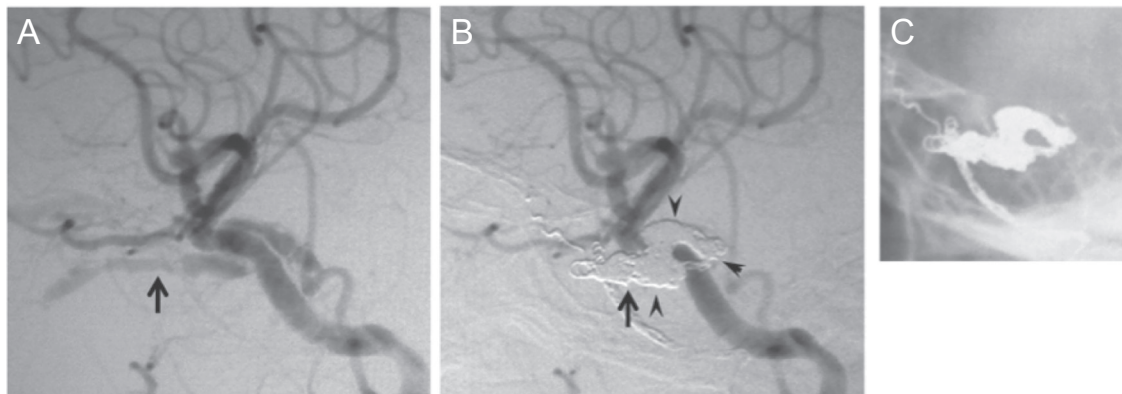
An 84-year-old man with cavernous sinus dural arteriovenous fistula (AVF) underwent transvenous embolization. A: Lateral view of left common carotid angiography showed cavernous sinus dural AVF fed by meningeal branches of the left internal carotid artery. The drainage routes was right superior and inferior ophthalmic vein (*arrow*), B: Ophthalmic vein was embolized with detachable coils (*arrow*). At the shunting compartment of cavernous sinus, five c-stopper coils (CSCs) were deployed by push technique (*arrow head*). The dural AVF was completely obliterated, C: Skull X-ray showing the coil mass.
